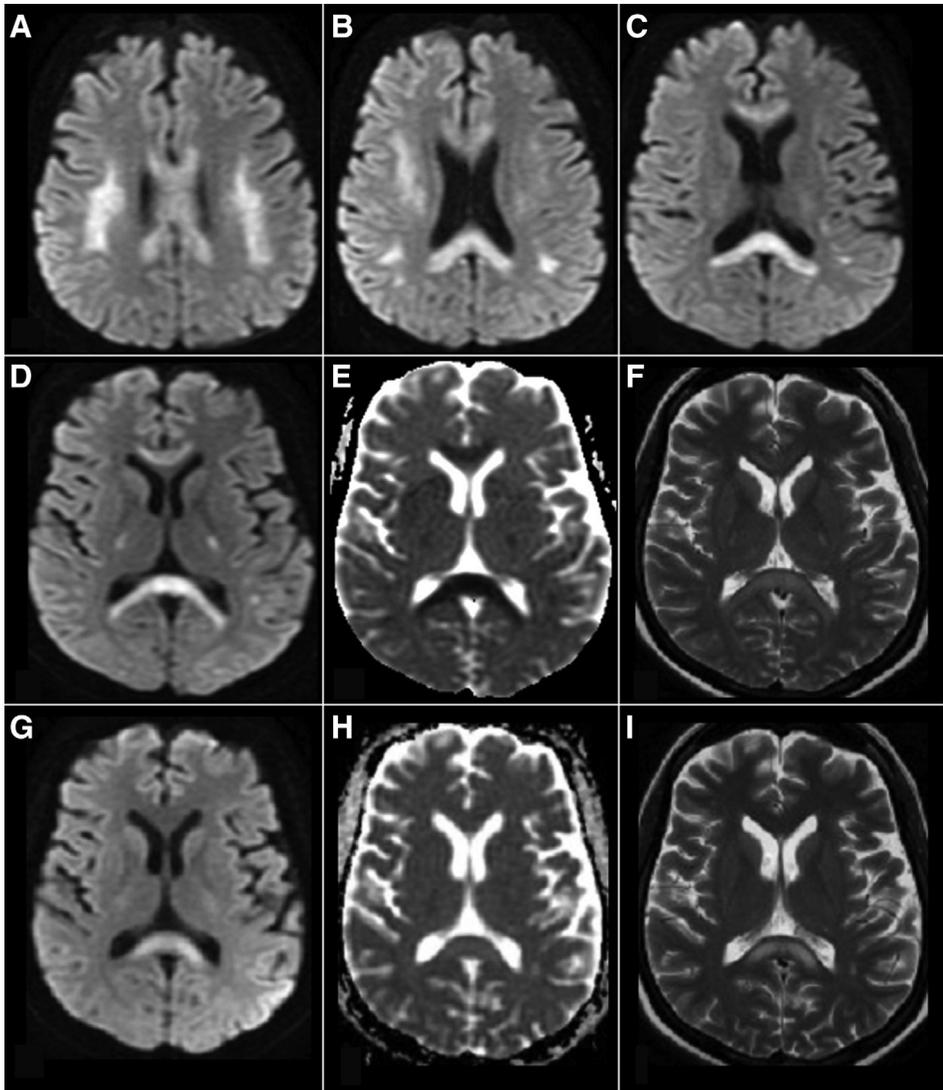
Diffusion weighted images (A-D) show hyperintensities in corpus callosum (A-D), centrum semiovale, and corona radiata (A, B), along posterior limbs of internal capsule (D). Apparent diffusion coefficient (ADC) image (E) confirms diffusion restriction, while T2 weighted image (F) shows less obvious hyperintensities. Repeat MRI taken on 29th day after chemotherapy (G-I) shows that changes in diffusion weighted image (G) have reduced considerably; ADC image (H) shows resolution of diffusion restriction; hyperintensity in splenium of corpus callosum on T2 weighted image (I) has become more prominent.
